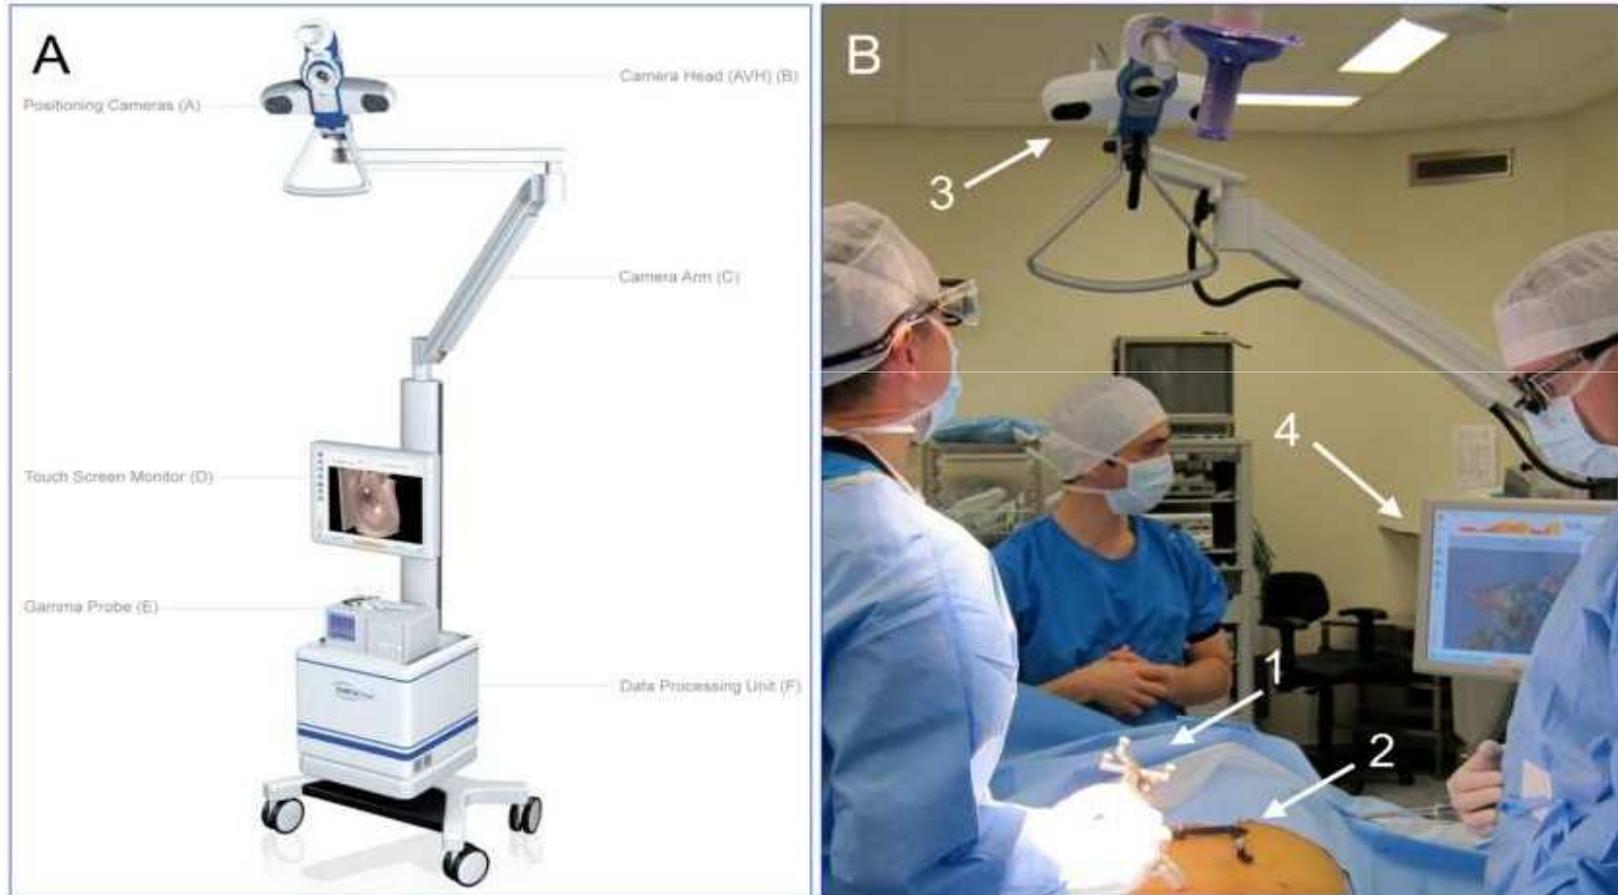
(A) Freehand SPECT system (SurgicEye, Munich, Germany) (B) Intraoperative setup and data acquisition using the freehand SPECT system with tracking targets on the gamma probe (1) and on the patient (2), which are monitored by the optical detection system (3), after which a reconstruction image can be displayed on screen (4).
